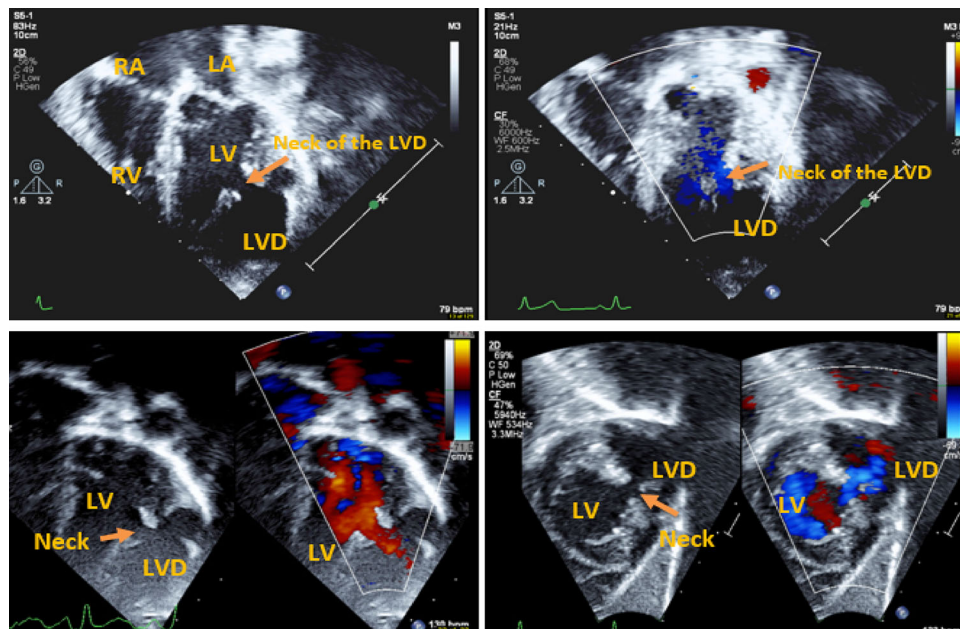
Four chamber and short axis views of the last follow up transthoracic Echocardiogram showing large left ventricular diverticulum (LVD) with no thrombus, and blood going into and out of it
